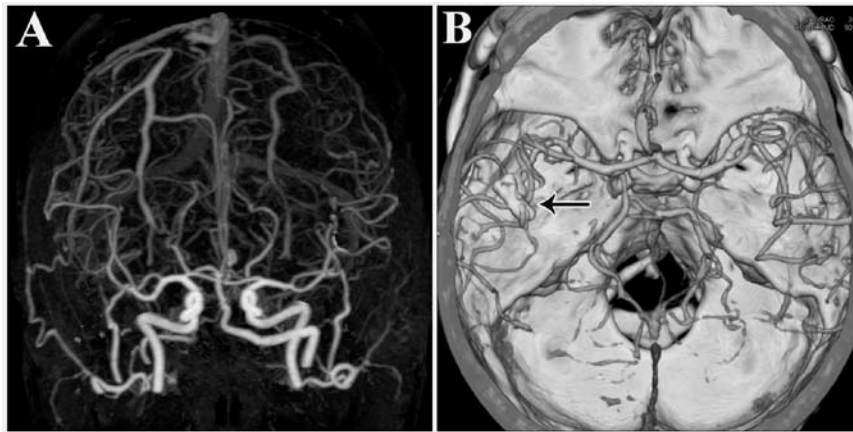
Postoperative CT angiography shows the occlusion of the aneurysms and the patency of the branches of the left middle cerebral artery (A & B). Two clips could also be seen (arrow).
